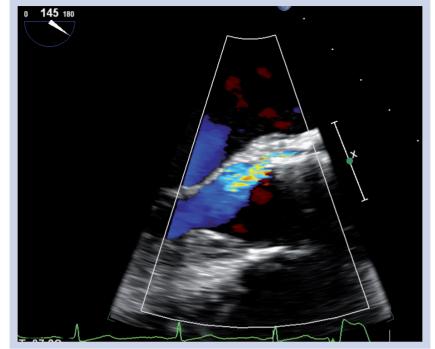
Paraprosthetic regurgitation: transesophageal echocardiography.
